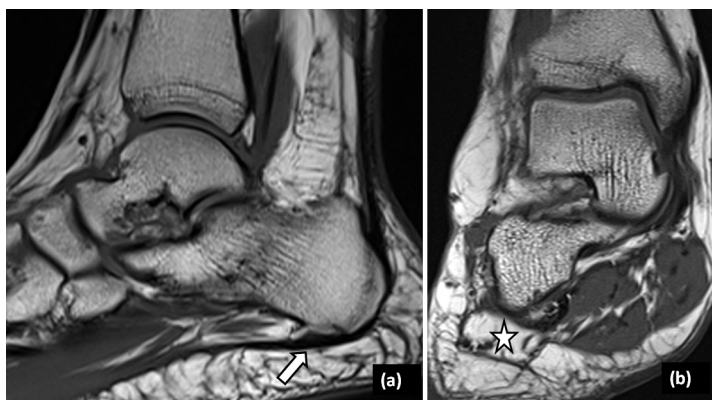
Sagittal (a) and coronal (b) T1-weighted images of a 41-year-old female patient with chronic heel pain are shown. The calcaneal spur at the inferior calcaneal process of plantar fascia insertion (arrow) and accompanying severe atrophy of adductor digiti minimi muscle (star in b) are compatible with Baxter's neuropathy.
